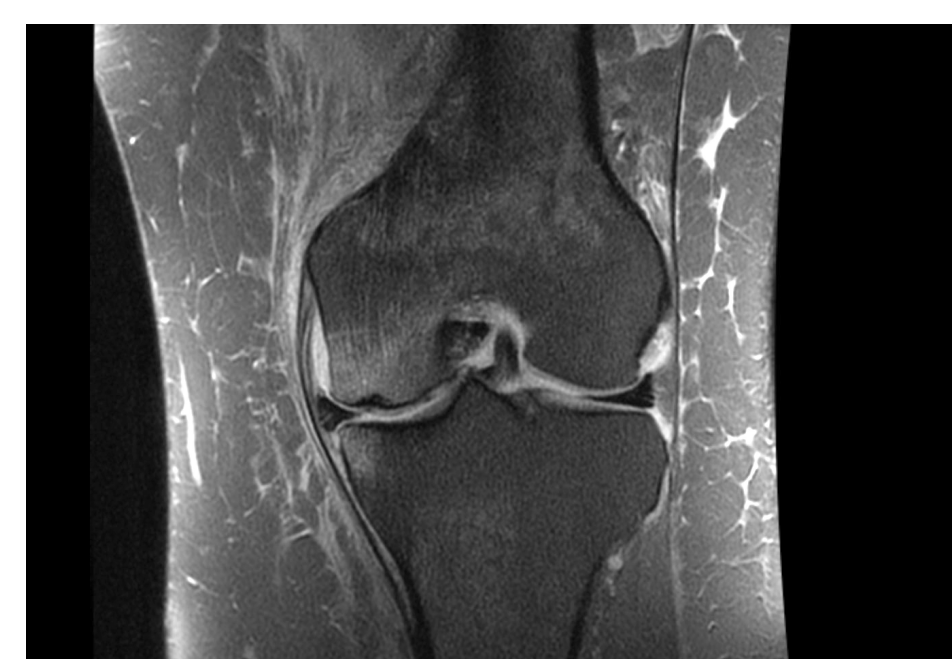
MRI Image of BME- Case 2
